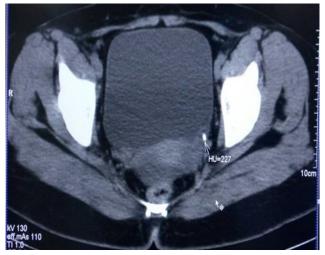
A CT image showing renal calculi with HU 227
